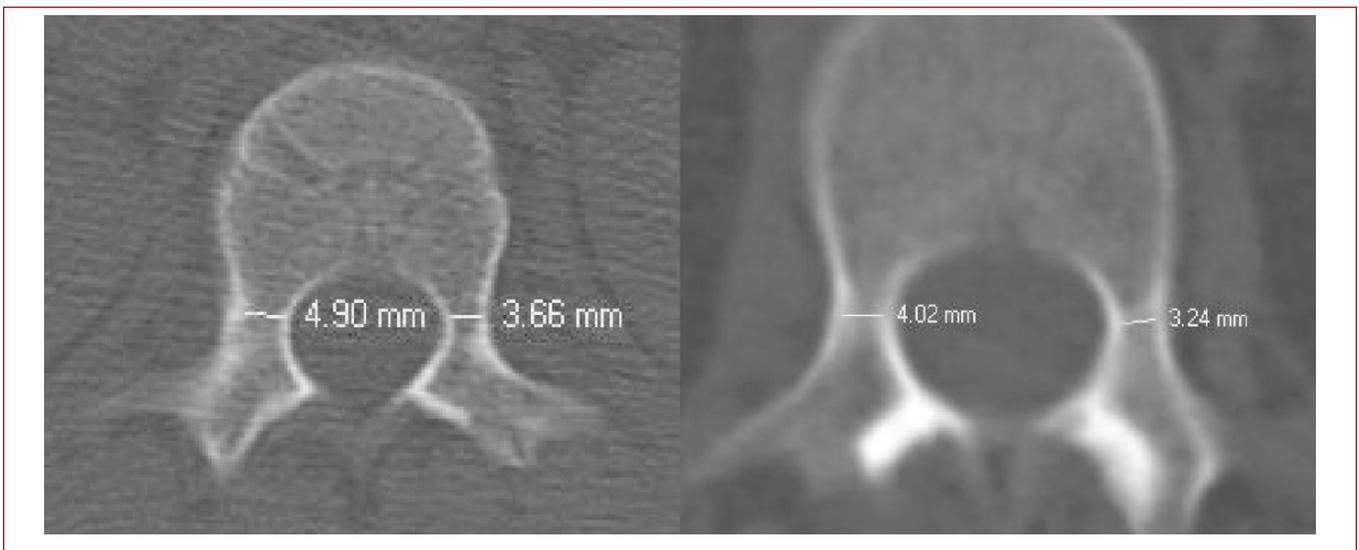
Measurement of T12 pedicle diameters by CT axial slices
